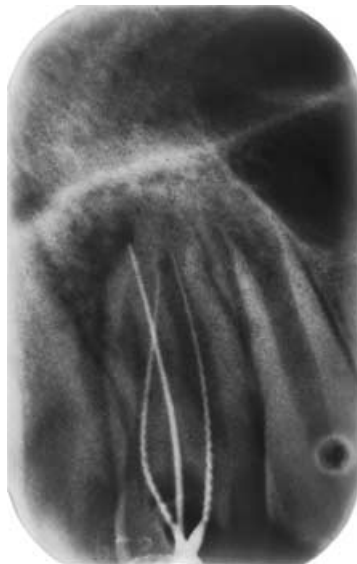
Radiographic assessment of the working length with two H-files of ISO-size 15 in the regular canals and one K-file (size 20) in the invagination canal.
